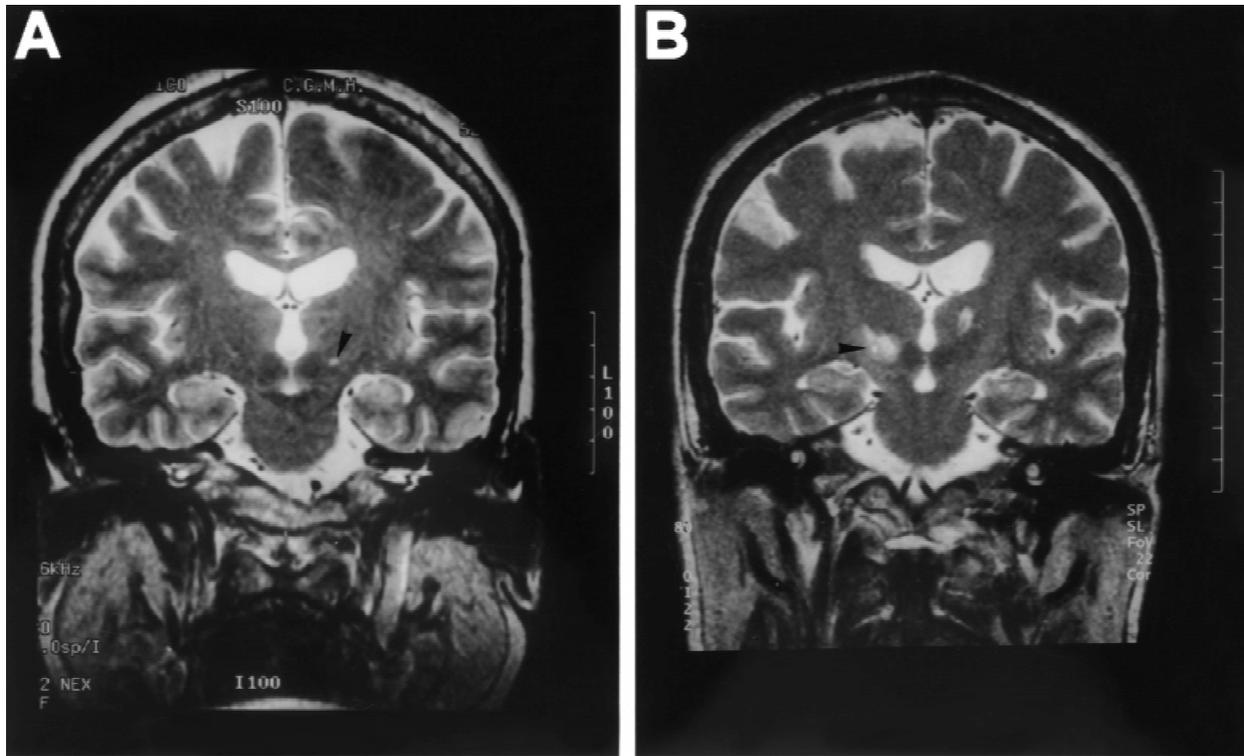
Two successive coronal T2-weighted magnetic resonance imaging scans clearly depict a 3×3 mm well-defined lesion (arrowhead) of the subthalamic nucleus (STN) in Patient 1 (A), and a 9×6 mm lesion (arrowhead) in the STN, involving the zona incerta, in Patient 2 (B), postoperatively.
